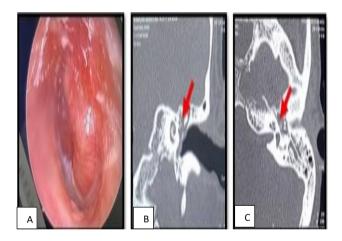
(A-C): Left-sided ear finding showing inflamed bulging tympanic membrane. HRCT temporal bone CT scan in coronal and axial plane showing erosion in facial canal in the tympanic segment.
